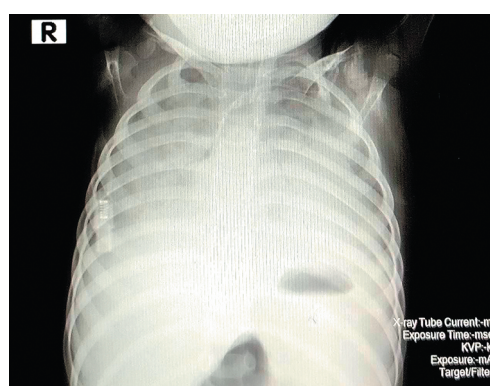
Chest radiography (4th day of hospitalization). Bilateral pneumonia. Pulmonary edema? (photo from the authors' personal archive)
